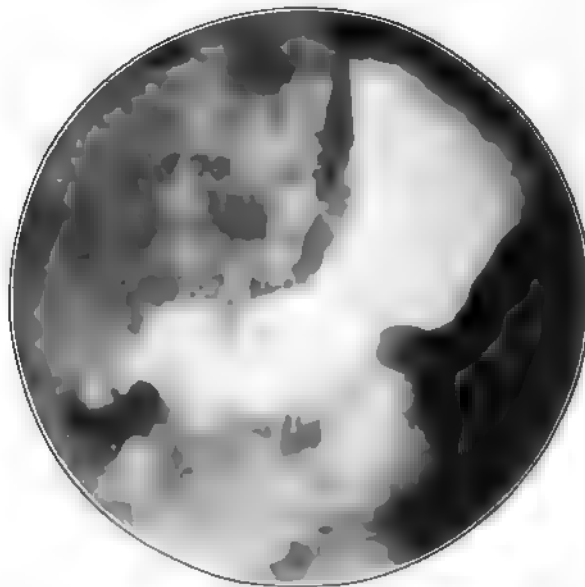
(108,061.) No retention from the six-hour barium motor meal. Hour-glass stomach. Roentgen diagnosis: Syphilis or ulcer of the stomach. Male, aged thirty-four years. Genital chancre, skin and mucous membrane secondaries twenty years previously. Gonorrhea three times. Gonorrheal arthritis. Chronic urethritis. Moderate alcoholism. Gastric disturbances two years. Cramping epigastric pains promptly after meals. Nausea and vomiting. Appetite fair. Loss of weight, 51 pounds. Liver and spleen palpable. Wassermann 3+. Achylia. Intravenous salvarsan four times. Mercurial inunctions and iodids. Treatment was begun July, 1914. January 5, 1915, symptomatically cured with a gain of 60 pounds. February 2, 1915, Wassermann 3+.
